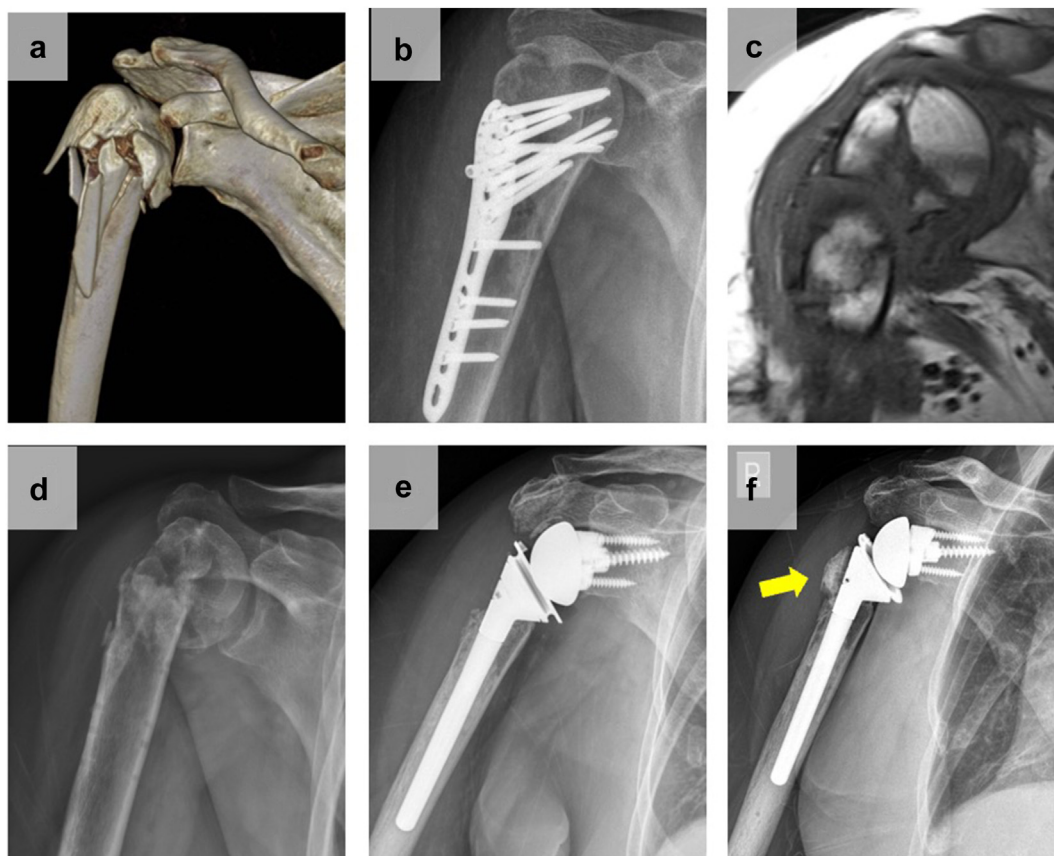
(a-f) Case 2, imaging studies. (a) Initial radiograph demonstrating a right comminuted proximal humeral fracture. (b) Status post ORIF with LCP. (c) and (d) Avascular necrosis, affecting the tuberosities and the metaphysis of the proximal humerus. (e) Radiograph after implantation of a RTSA; in the absence of a greater tuberosity and posterior rotator cuff, the patient presented an ER lag and a positive Hornblower's sign. (f) One-year radiograph after supplement LTT+. The yellow indicates the calcaneal bone block which appears united with the proximal body of the prosthesis and the humeral shaft. ER, external rotation; LTT, lower trapezius transfer; ORIF, open reduction and internal fixation; RTSA, reverse total shoulder arthroplasty.
